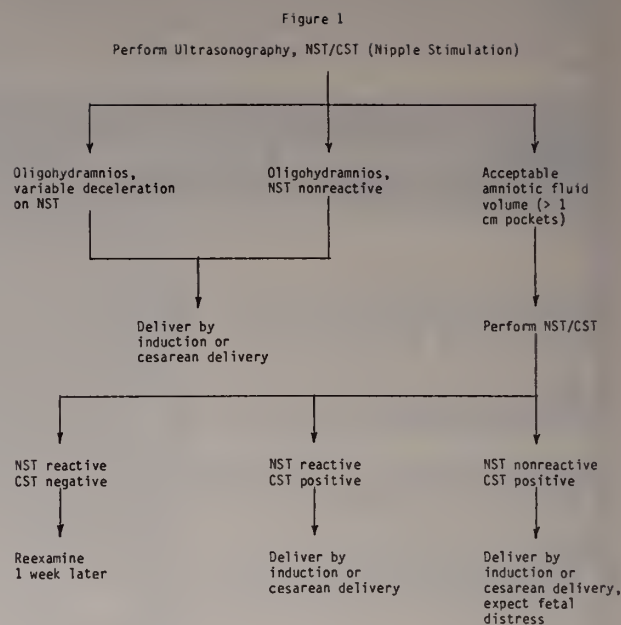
Perform Ultrasonography, NST/CST (Nipple Stimulation).
